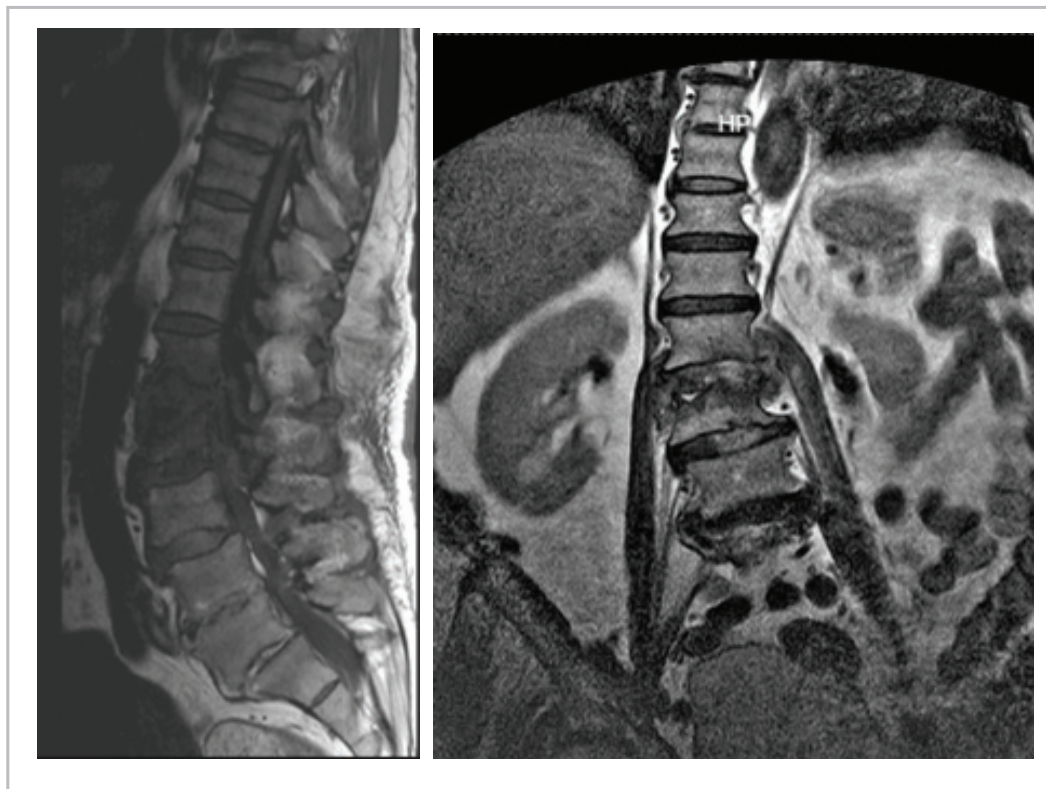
Magnetic resonance imaging of the lumbosacral spine with contrast. Longitudinal and coronal section. Source: patient.
